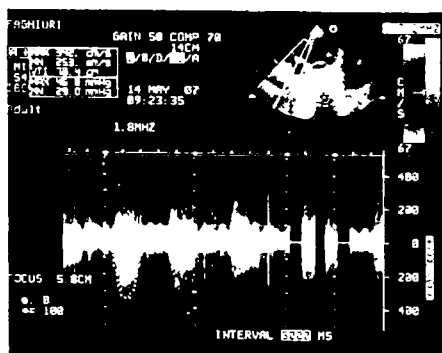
Spectral Doppler - severe tricuspidian insufficiency
